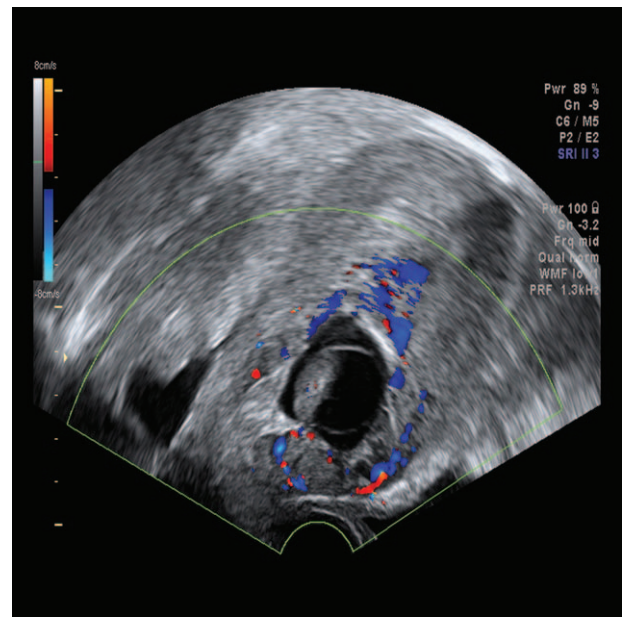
Transvaginal 2-dimensional color ultrasound image of cesarean scar pregnancy.
